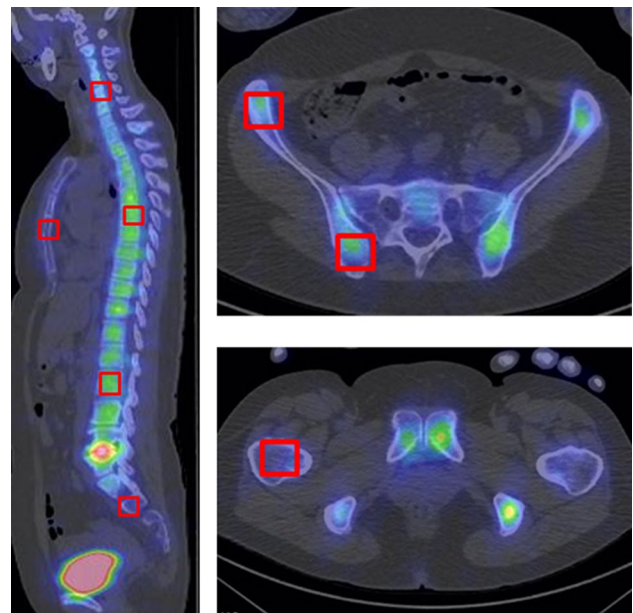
Measurement of SUV_{max} for bone accumulation at 8 normal bone sites in subjects without bone metastases on ^{99m}Tc -methylene diphosphonate SPECT/CT. For this analysis, cubic volumes of interest with 20 mm edges were placed over 8 sites of normal bone, comprising the 4th cervical, 6th thoracic, and 3rd lumbar vertebral bodies, sacrum, sternum, right anterior and posterior iliac bone, and intertrochanteric right femoral bone, in each subject
